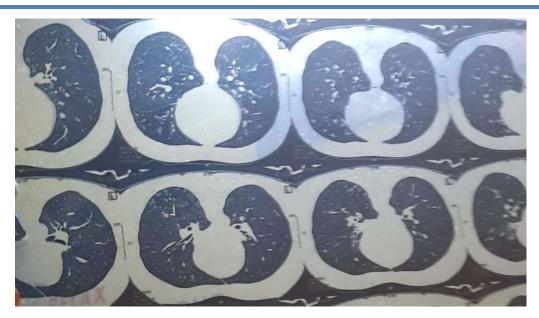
CT scan showing the presence of multiple areas of centrilobular micronodules with a linear branching pattern that resembled a budding tree.
